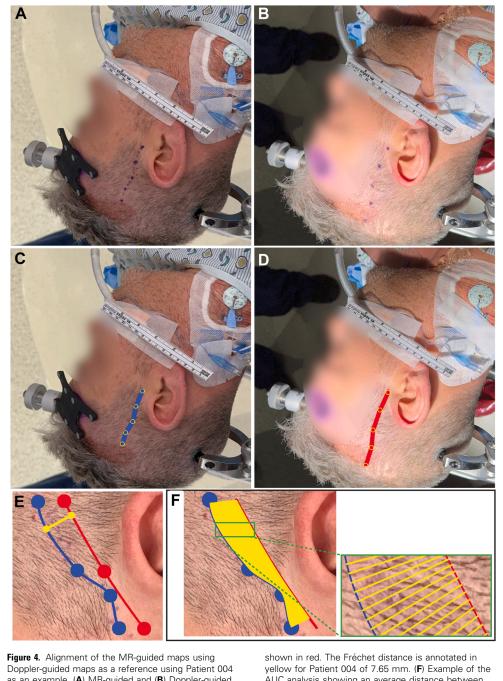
Alignment of the MR-guided maps using Doppler-guided maps as a reference using Patient 004 as an example. (A) MR-guided and (B) Doppler-guided maps. (C) Annotated MR and (D) Doppler maps using computer vision assuming a 5-mm thickness. (E) Overlay maps, with MR shown in blue and Doppler
